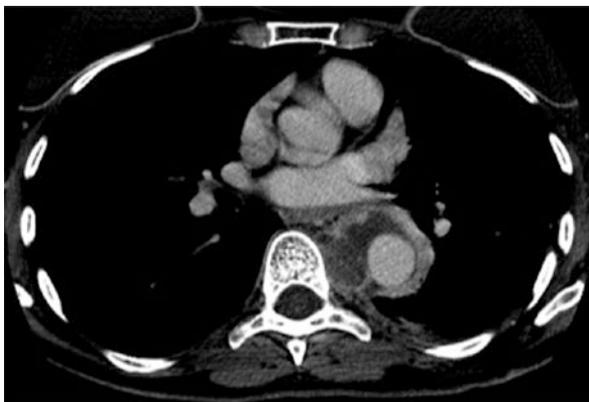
Synovial sarcoma. Heterogeneous mass with a low attenuation core and peripheral enhancement on CT scan, surrounding the descending aorta and appended to the thoracic vertebral body. Pathology of the CT-guided biopsy sample led to the diagnosis of synovial sarcoma
